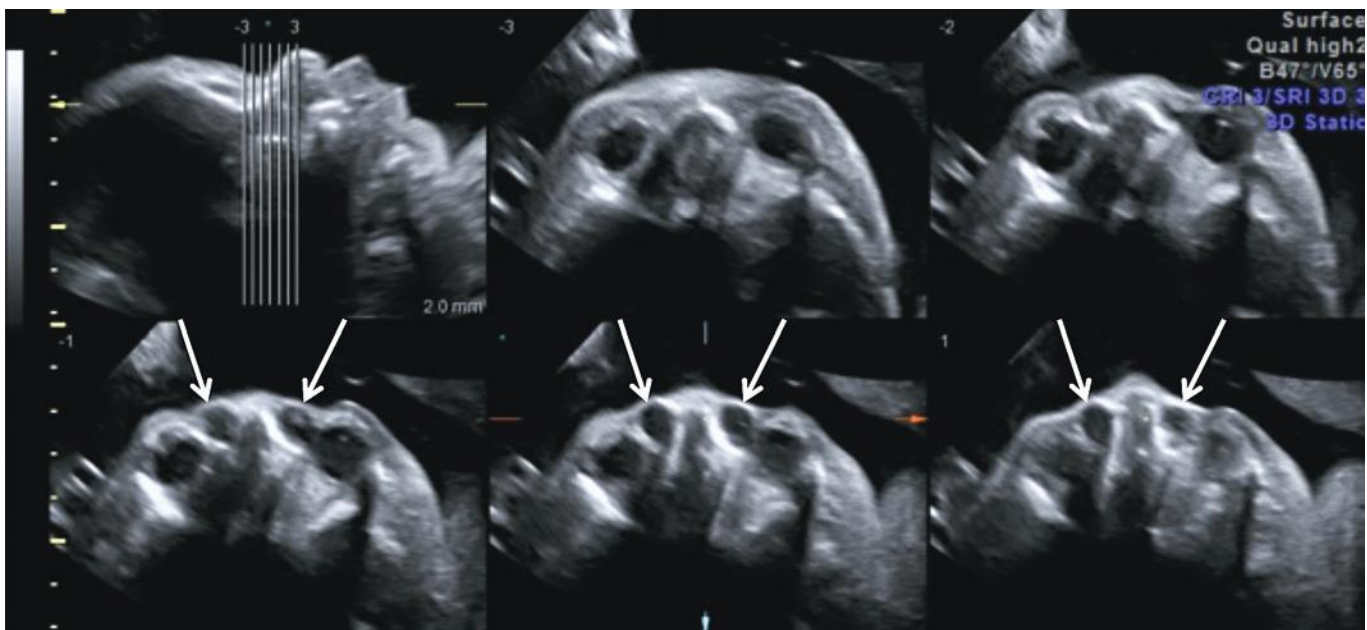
Bilateral dacryocystoceles: Tomographic ultrasound imaging (multiple parallel slices) through fetal face demonstrating orbits and dacryocystoceles (arrows).
